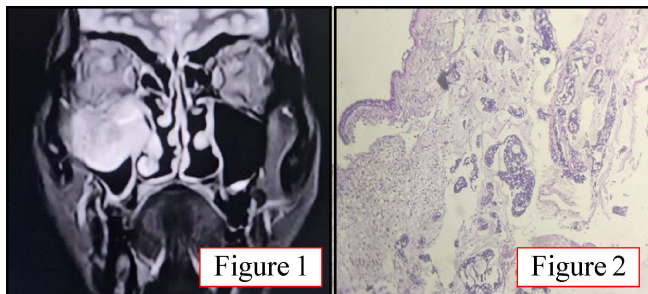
Shows the radiological image (Computed tomography) a polypoidal, heterogenous, hyperintense mass occupying the supero-posterior aspect of right maxillary sinus.
